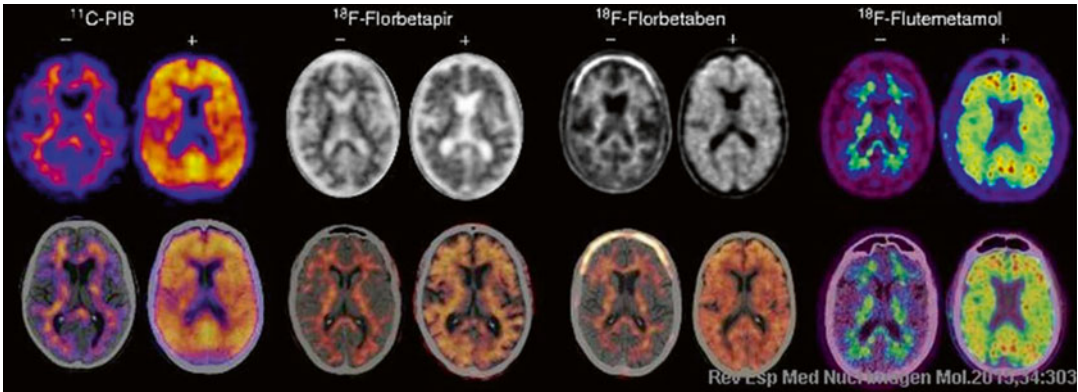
Representative positive (+) and negative (-) PET (top row) and PET-CT (down row) images obtained with different Aβ radiotracers. From left to right: 11C-PIB, 18F-florbetapir, 18F-florbetaben, and 18F-flutemetamol (From Arbizu et al. [17], with permission from Elsevier)
